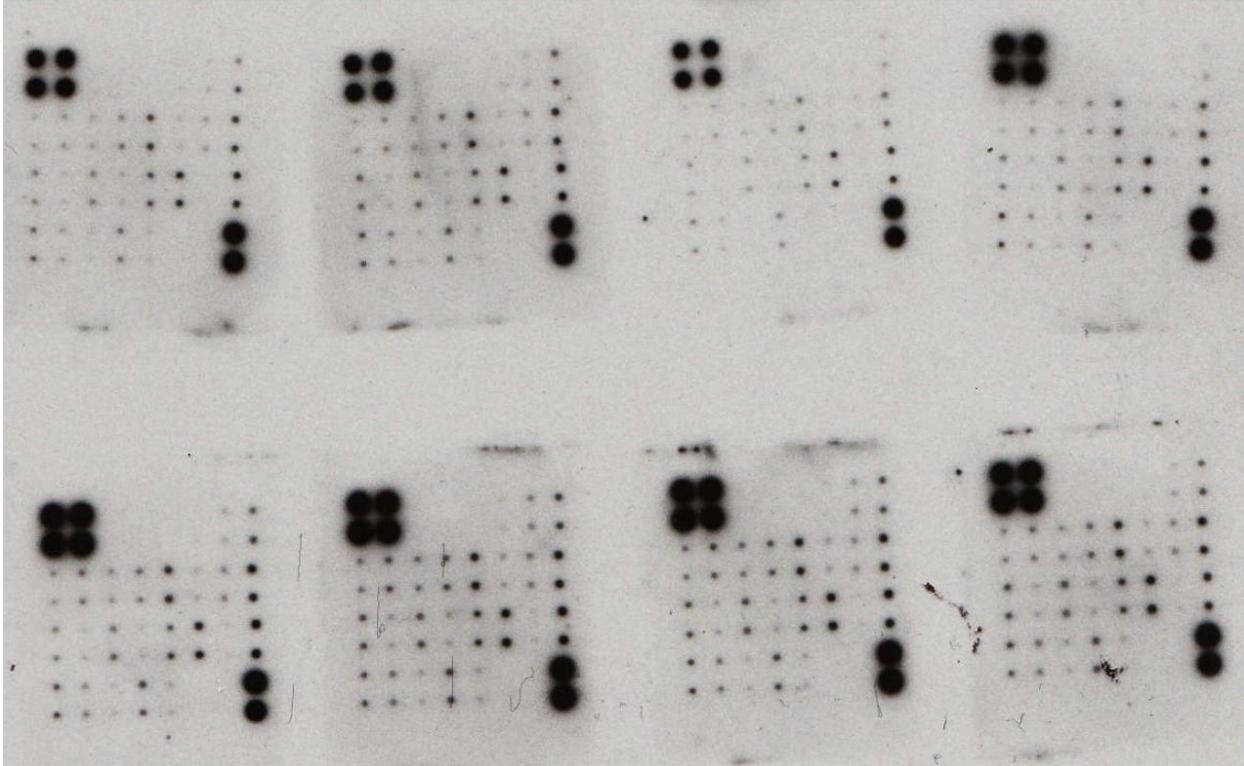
X-rayed image of membrane assay. 8 total cytokine detection membrane assays were completed. The top row represents four, randomly selected, 28 week old control untreated brain homogenates; the bottom row represents four, randomly selected, diseased untreated brain homogenates. These homogenate samples are from Table 2.
